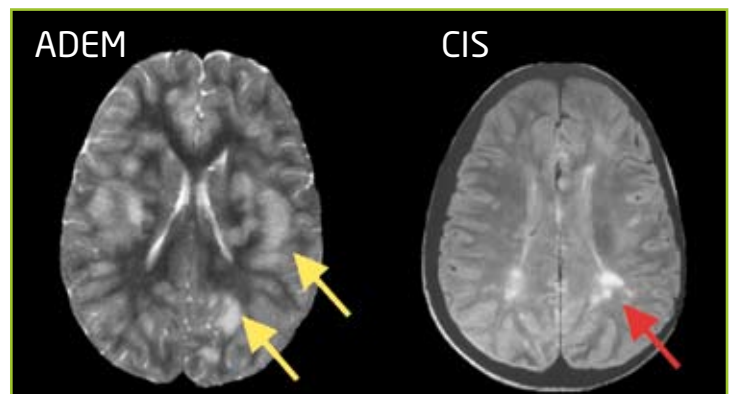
Comparison between magnetic resonance imaging in ADEM and in CIS. A child with ADEM (left) presented symptoms suddenly with unconsciousness and large patches of inflammatory demyelination in the white matter (yellow arrows). An adolescent with CIS (right) displayed symptoms more slowly with abnormal sensation in one arm (CIS) and had smaller white matter lesions (red arrow). This patient (CIS, right) progressed to multiple sclerosis.
